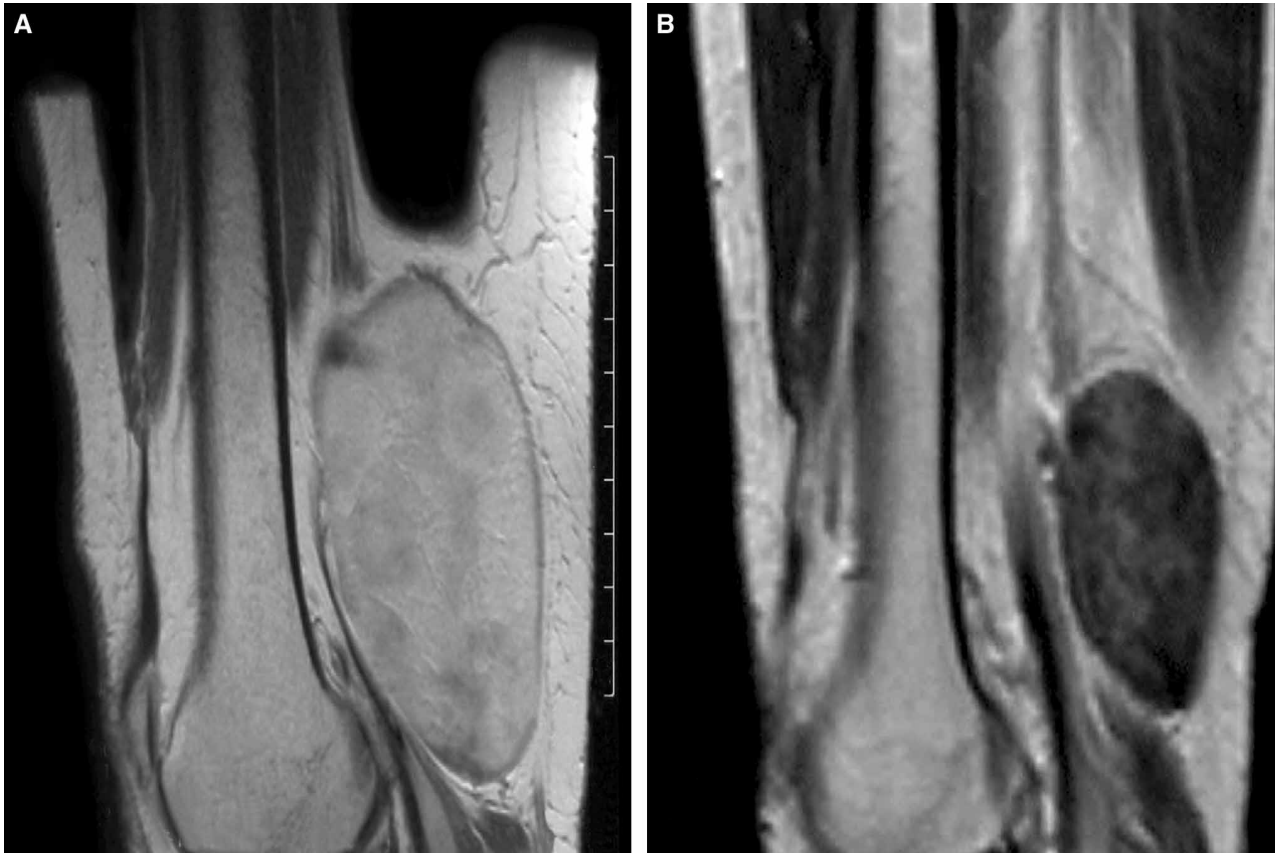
MRI of patient no. 7 with intramuscular MLS in the distal thigh. A: Pre-irradiation: T1 weighted sagittal image after Gd-DTPA contrast shows well-defined tumour with rather homogenous and intense enhancement. B: Post-irradiation: Considerable reduction in tumour volume (81%) as well as in enhancement intensity.
